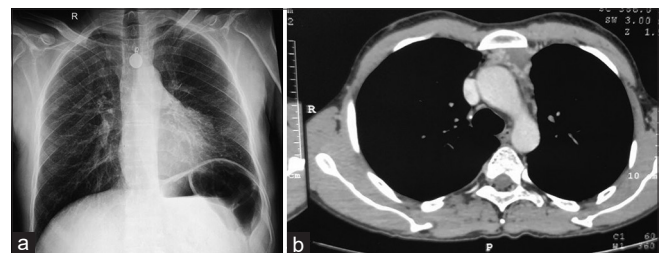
Chest X-ray posteroanterior view showing a heterogeneously enhancing mass lesion in the left lower zone, pleural effusion, and cardiomegaly
